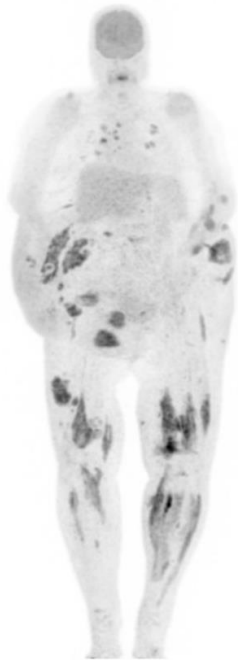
FDG-PET demonstrating FDG-avid lesions in subcutaneous and muscle tissues of forearms, lower torso and lower limbs, and FDG-avid pulmonary nodules and right hilar lymphadenopathy.
